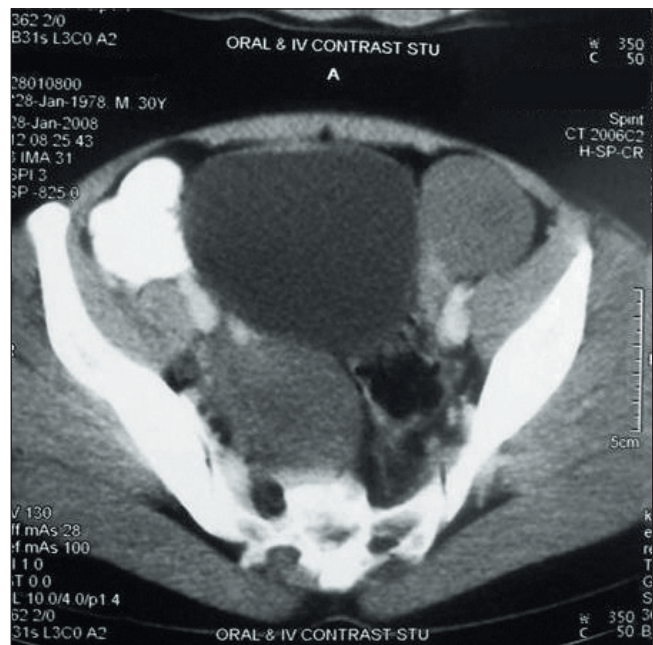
CT scan showing enlarged testis in the left iliac fossa and pelvis.
